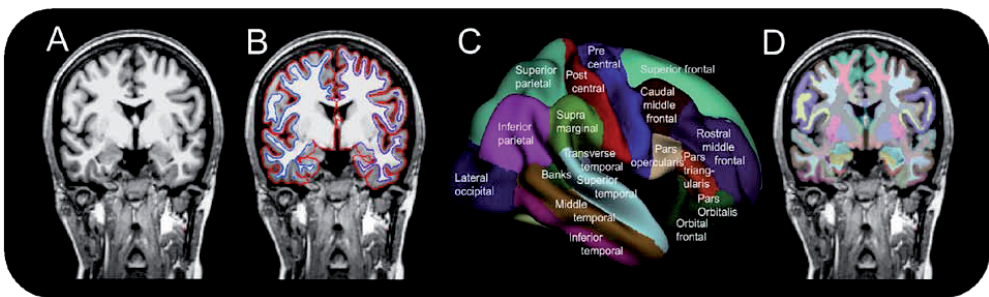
Neuroanatomical parcellation of the brain surface. A) A coronal section of a T1-weighted MRI volume. B) Automatic reconstruction of the boundaries between gray and white matter and between gray matter (blue) and cerebrospinal fluid (red). C) The result of the automatic surface-based parcellations scheme. D) T1-weighted MRI volume automatically segmented into neuroanatomical cortical and subcortical regions.
